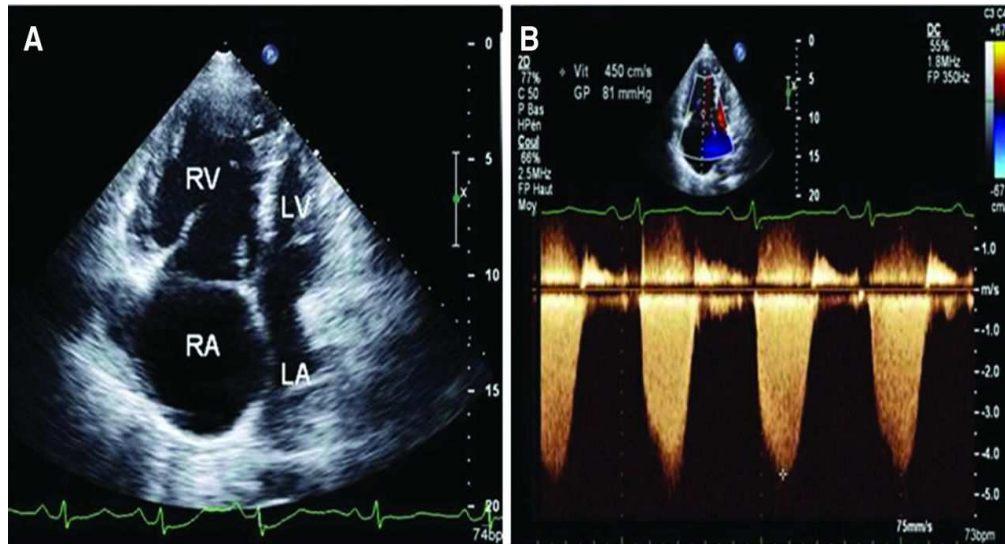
Echocardiogram, A,B,C
